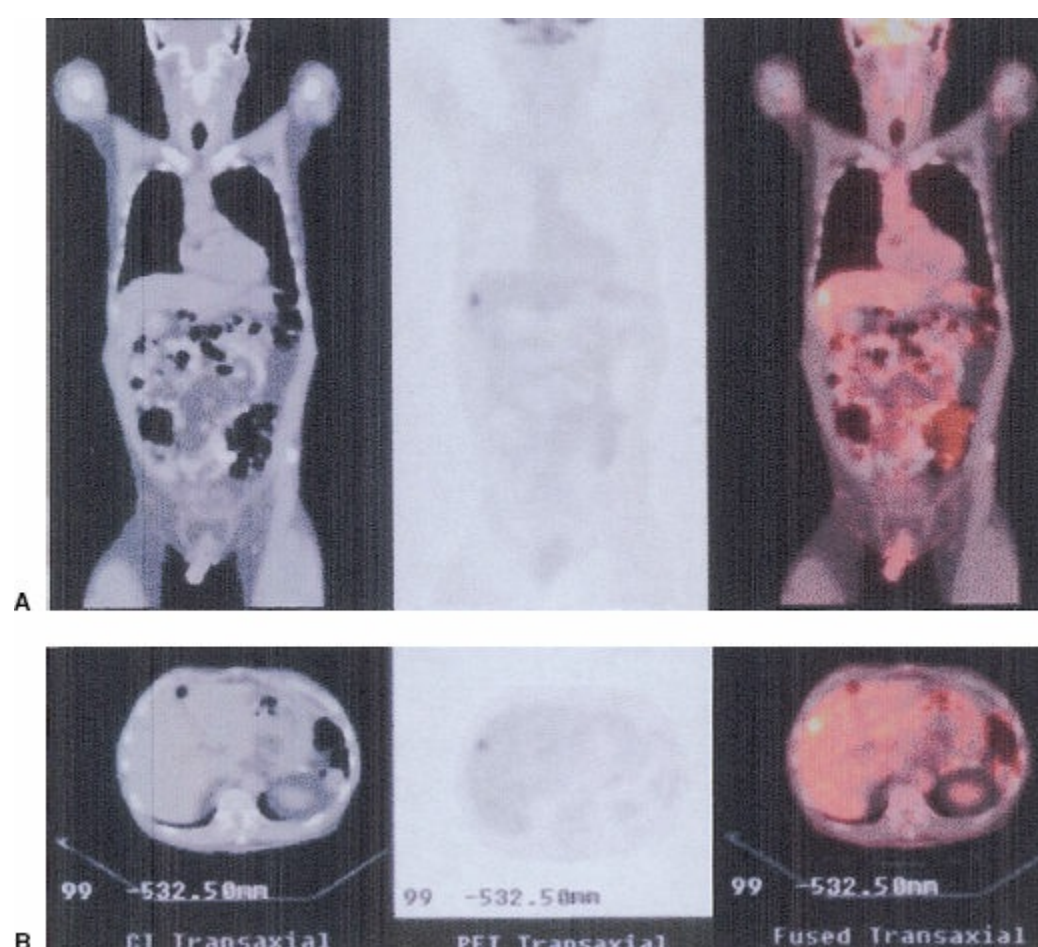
Positron emission tomography and computed tomography (PET-CT) scan images of patient in Figure 57-18B and C with solitary gastrointestinal stromal tumor metastasis straddling segments IV and V. Noncontrast CT images (left). PET images (center). Fusion images (right).
